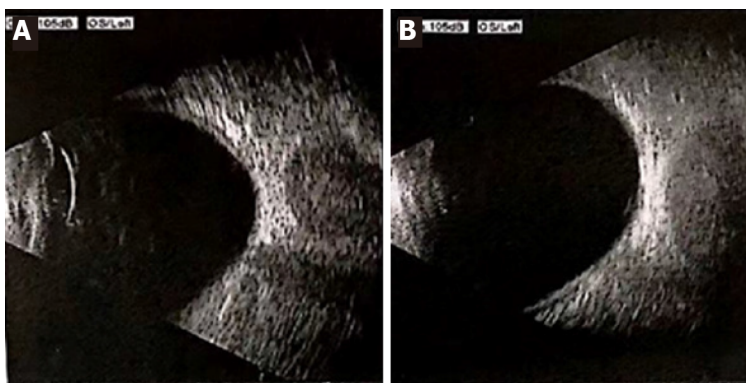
Ocular ultrasound of the left eye. A, B: Ocular Ultrasound showed that the echo of the posterior eyeball mass of the left eye is uneven, and it disappears while the gain reduced, suggesting there was a goitre of the left orbit.
